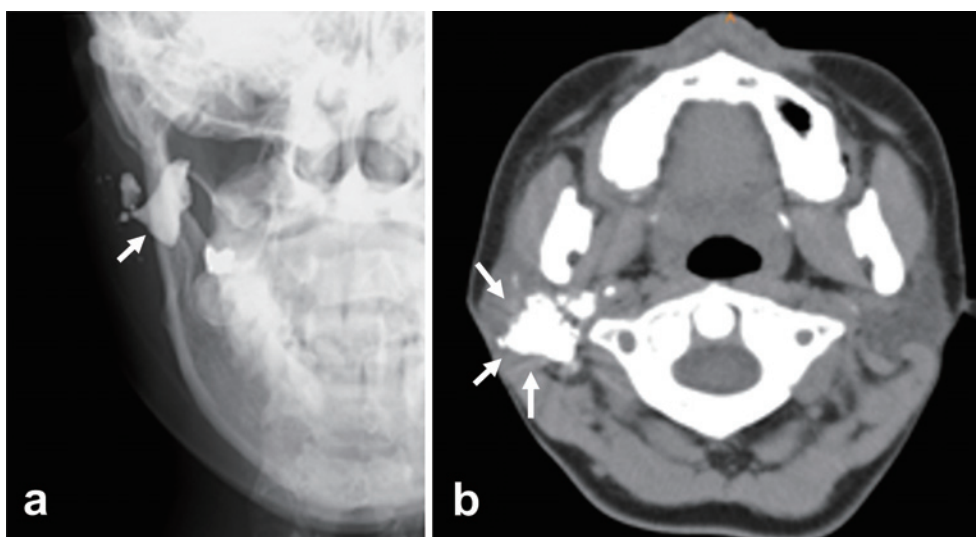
Images from the CT test
